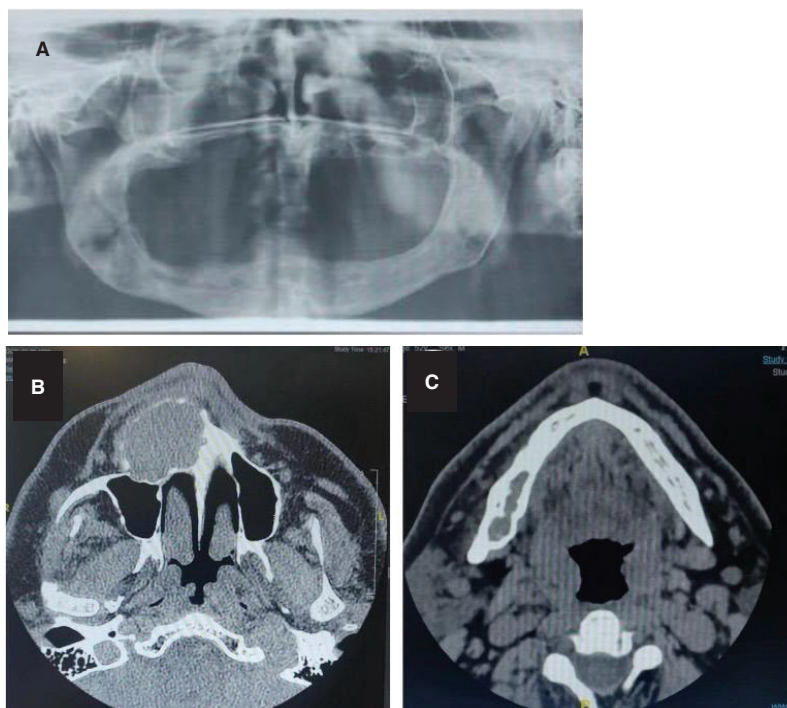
Pre (A) OPT; (B) Maxilla CBCT; (C) Mandible CBCT
